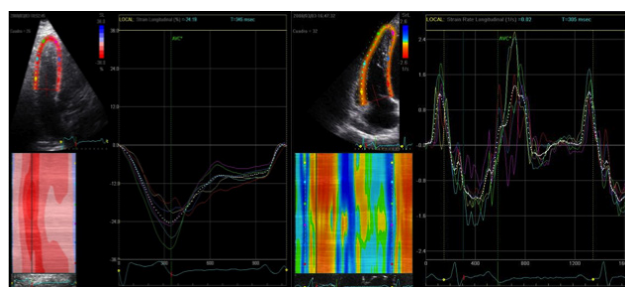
Right ventricle longitudinal strain and strain rate from apical 4 chamber view.
